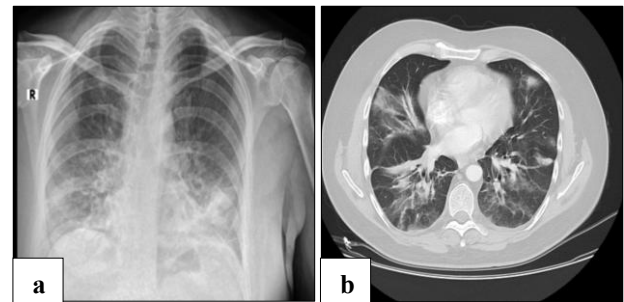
(a and b): Bilateral basal infiltrates on posteroanterior chest radiography, Prominent ground-glass opacities in the basal regions on thoracic computed tomography.
